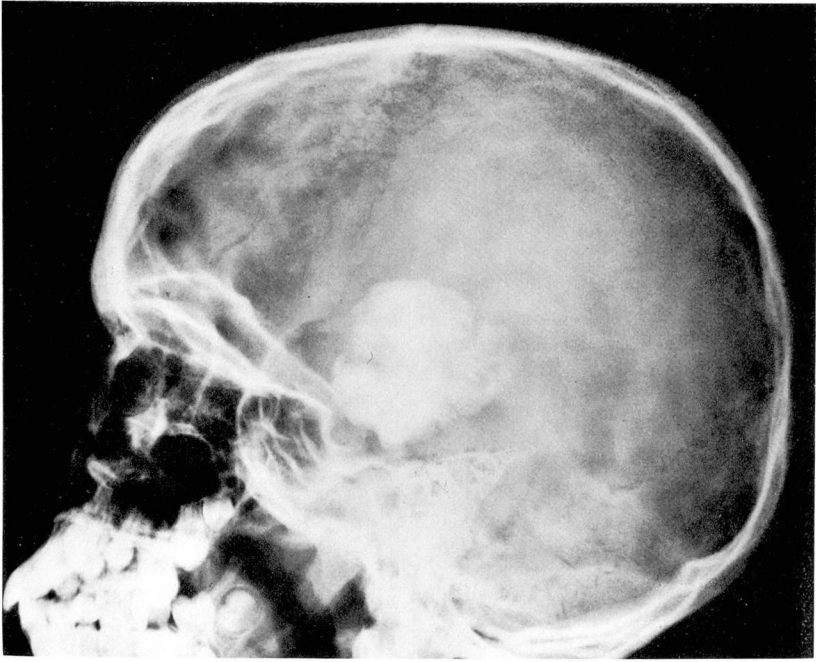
Case 7. Plain skull roentgenogram, lateral view showing large temporal calcified mass.
